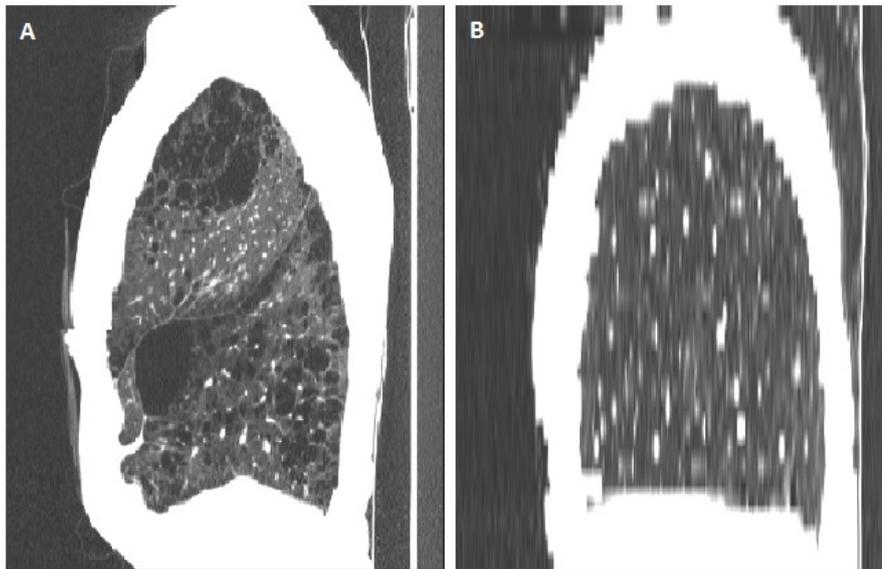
Patients diagnosed with emphysema showed in A) HRCT of 1,5mm slices and in B) CT of 5mm slices.
